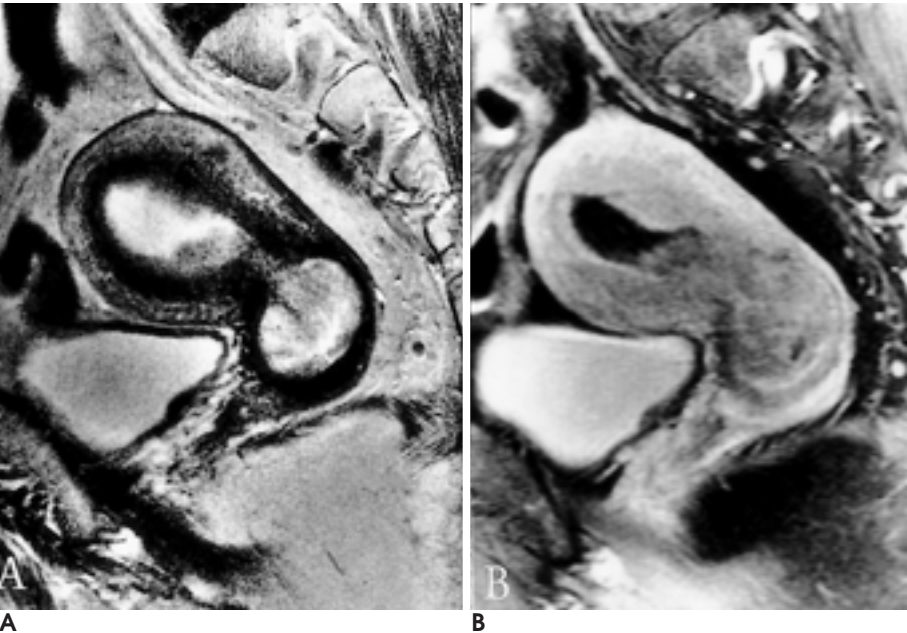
Cervical carcinoma involving endocervix shows invasion of the endometrium without destruction of junctional zone on sagittal T2-weighted image(A) and fat-suppressed Gd-enhanced T1-weighted image(B).
